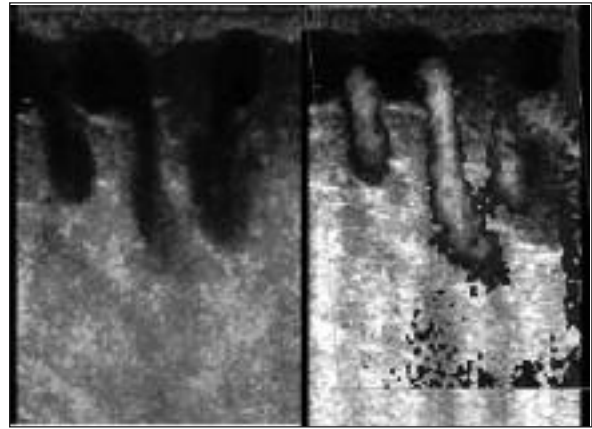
A superficial varicose vein is shown by Doppler ultrasound below the right knee corresponding to the site of focal increased persistent abnormal uptake on the ^{99m}Tc -HIG study.
